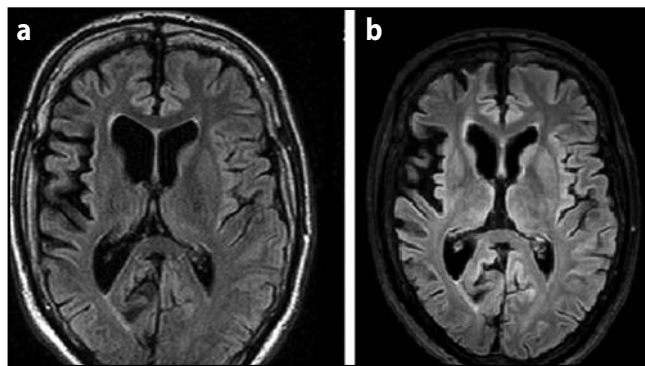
FLAIR MRI of patient in year 2012 (a) and 2015 (b). No significant progression of atrophy of right hemisphere is present.
